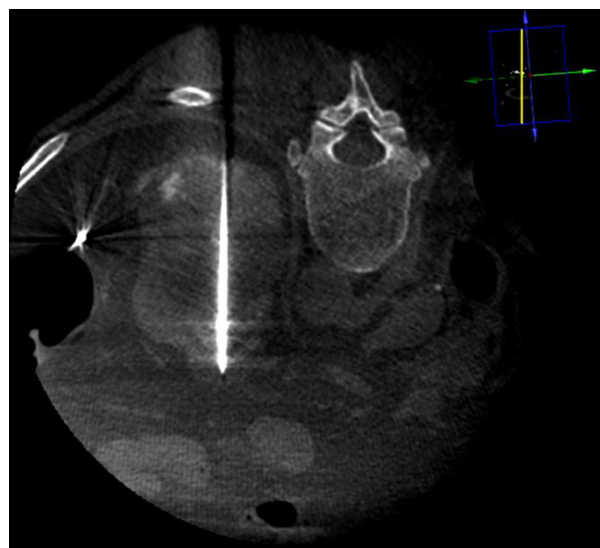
Cone-beam CT and fluoroscopic-guided microwave ablation. Microwave ablation probes were inserted under fluoroscopy with XperGuide overlays. The probe was advanced another 1 cm prior to ablation.
